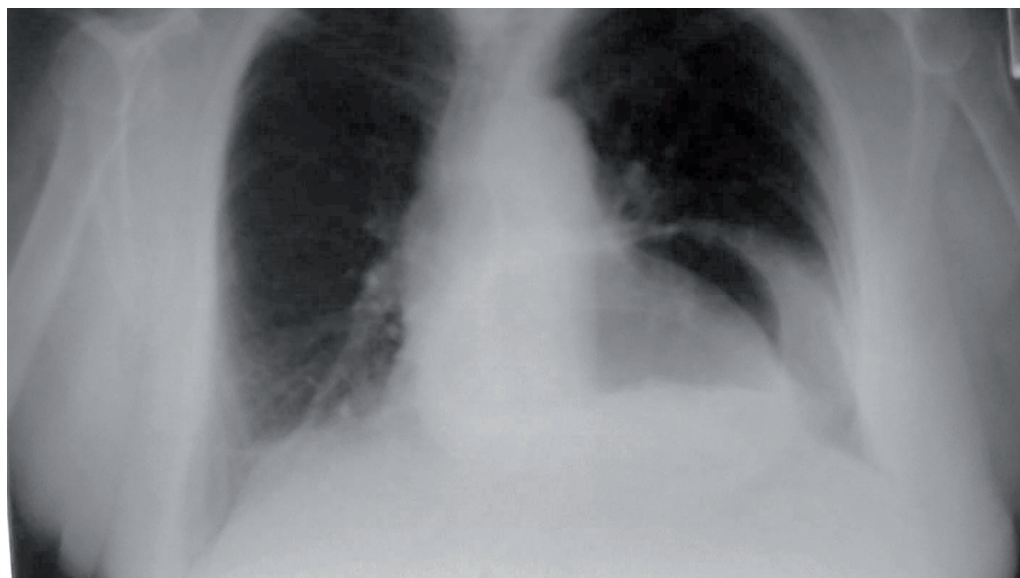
PA chest radiograph of the upside-down stomach.
